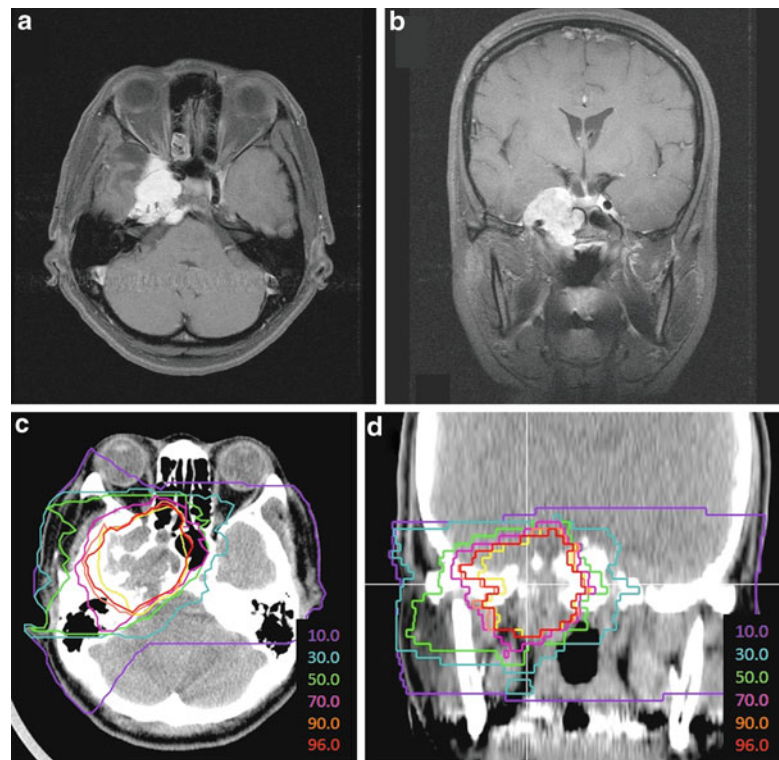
(a) Axial contrast-enhanced T1-weighted magnetic resonance image at the level of temporal lobe obtained 26 months after carbon ion radiotherapy. (b) Axial contrast-enhanced T1-weighted
